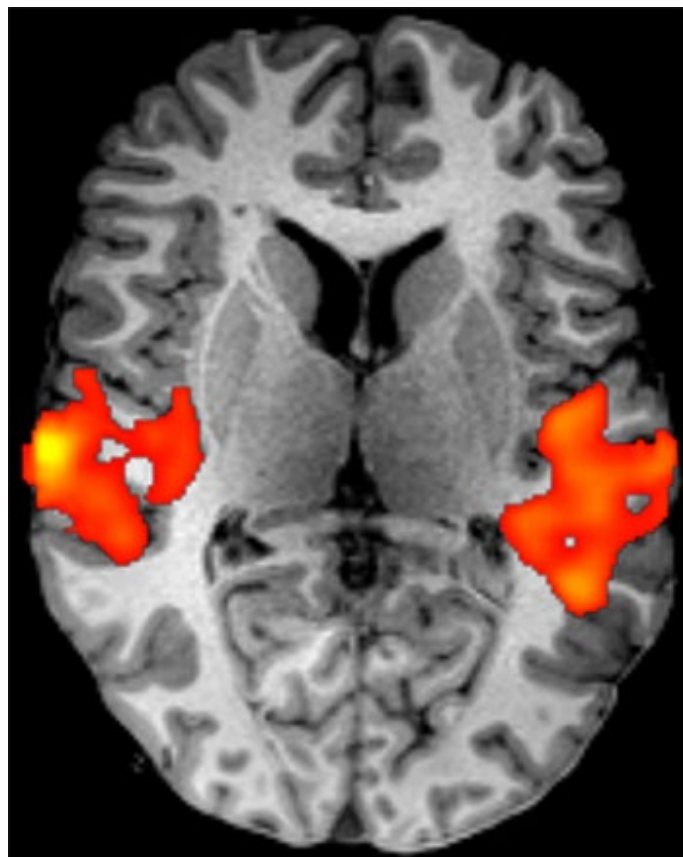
This functional MRI scan was acquired from a patient in the ICU who had been struck by a car. Though he was determined to be minimally conscious, the scans showed that language-associated areas of his brain activated (orange in the scan) when speech was played to him through headphones. He eventually fully regained consciousness.
